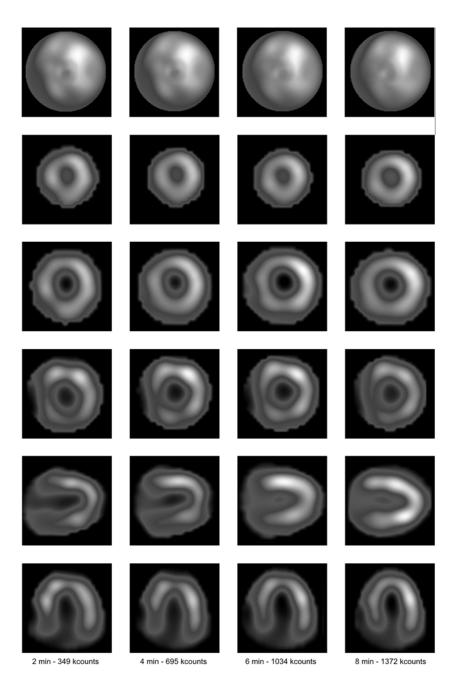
An example of stress MPI using CZT-SPECT scans with varying scan times: from left to right, images of the 2, 4, 6 and 8 minute scan with their corresponding measured photon counts. The scans are from a typical patient (55 year-old female, 61 kg, BMI 21.1 kg/m², administered with 187 MBq). The corresponding bull's-eye, three slices of the short axes (from apical to basal), the vertical long and horizontal long axes are shown from top to bottom. For all axes, the same locations are shown for each scan time.
